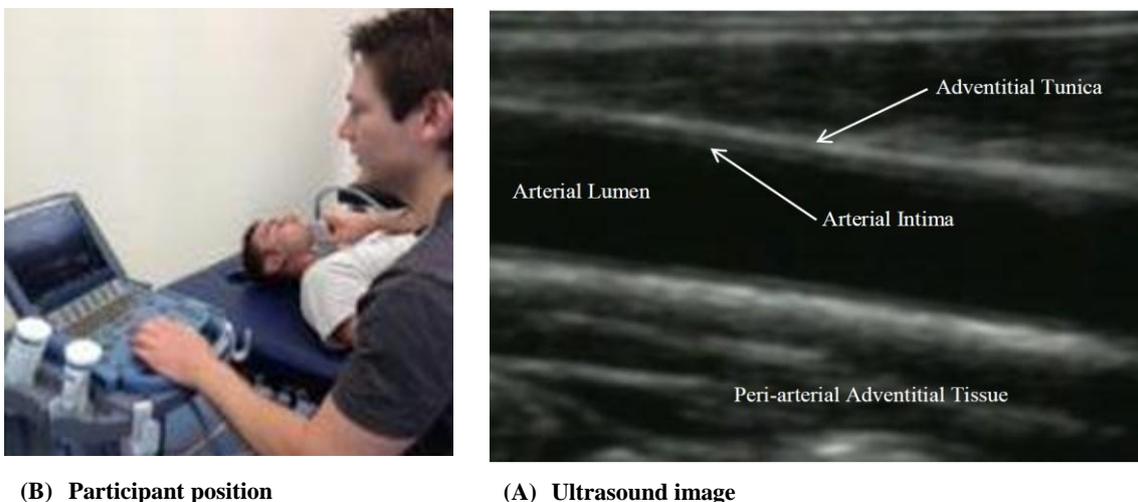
Local arterial stiffness and haemodynamic assessments. (A) Participants lay supine with their head tilted 45° away from the examined right side. (B) Magnified ultrasound image of the common carotid artery.
